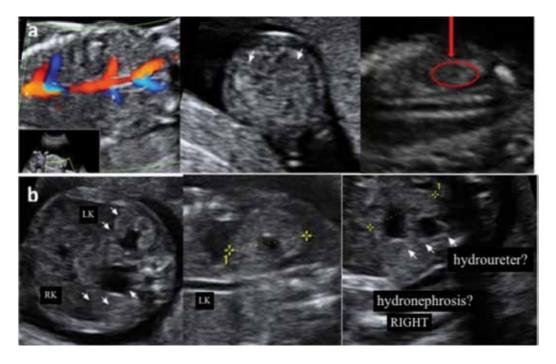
(a) First trimester: both renal arteries visualized in color Doppler, normal kidney images on both sides of the cross section and a kidney highlighted in the coronal section. (b) Second trimester (same case): asymmetrical bilateral pyelectasis, left kidney longitudinal diameter and hydroureter on the right side.
